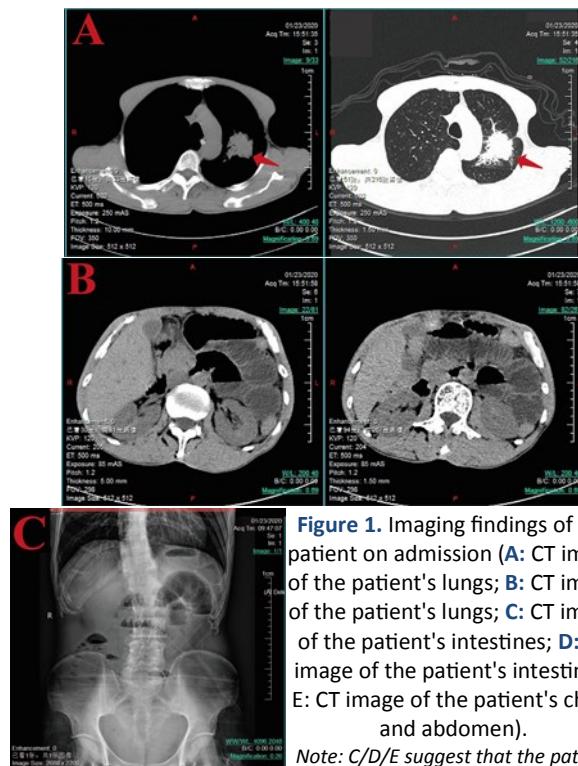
Imaging findings of the patient on admission (A: CT image of the patient's lungs; B: CT image of the patient's lungs; C: CT image of the patient's intestines; D: CT image of the patient's intestines; E: CT image of the patient's chest and abdomen).
